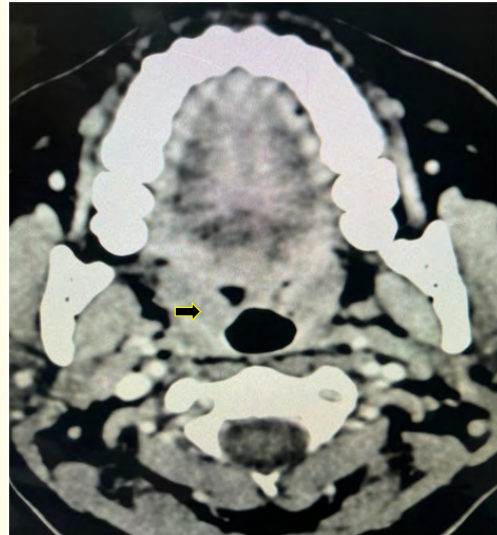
CT (computed tomography) scan showing a well-circumscribed, soft tissue density inside the right tonsil compatible with a lipoma.
